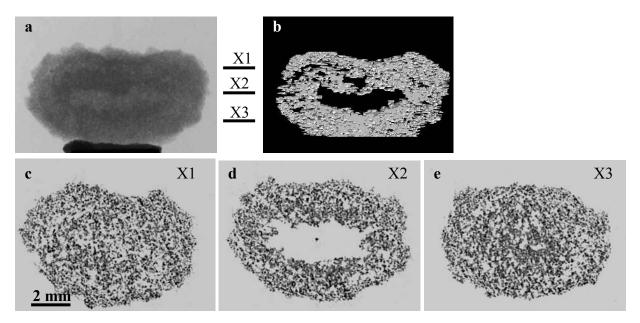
Granule A: a) typical side view X-ray image, b) vertical cross-sectional slice (3-d reconstruction, mannitol is gray), c-d) reconstructed 2-d horizontal slices X1-X3 (Mannitol is dark gray); slice thickness is 80μm in b) and 11μm in c)-e).
